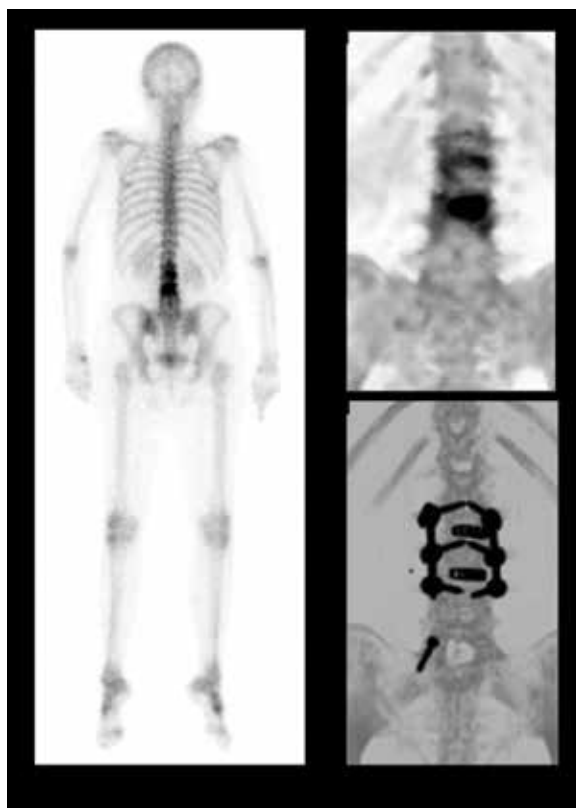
Planar bone scan shows increased uptake in the bodies of L4 and L3 vertebrae. xSPECT Bone maximum intensity projection (MIP) shows gross increase in tracer uptake in the upper part of the body of the L4 vertebrae and the L3-L4 intervertebral disc level, as well as mildly increased uptake in the L2-L3 intervertebral disc space. MIP of CT shows the orientation of the lumbar interbody fusion screws and end plates through the facets and bodies of L2, L3 and L4 vertebrae, as well as interbody cages in L2-L3 and L3-L4 intervertebral disc spaces. The solitary screw fusing right L5 facet to S1 reflects past surgery without evidence of any osseous stress.
